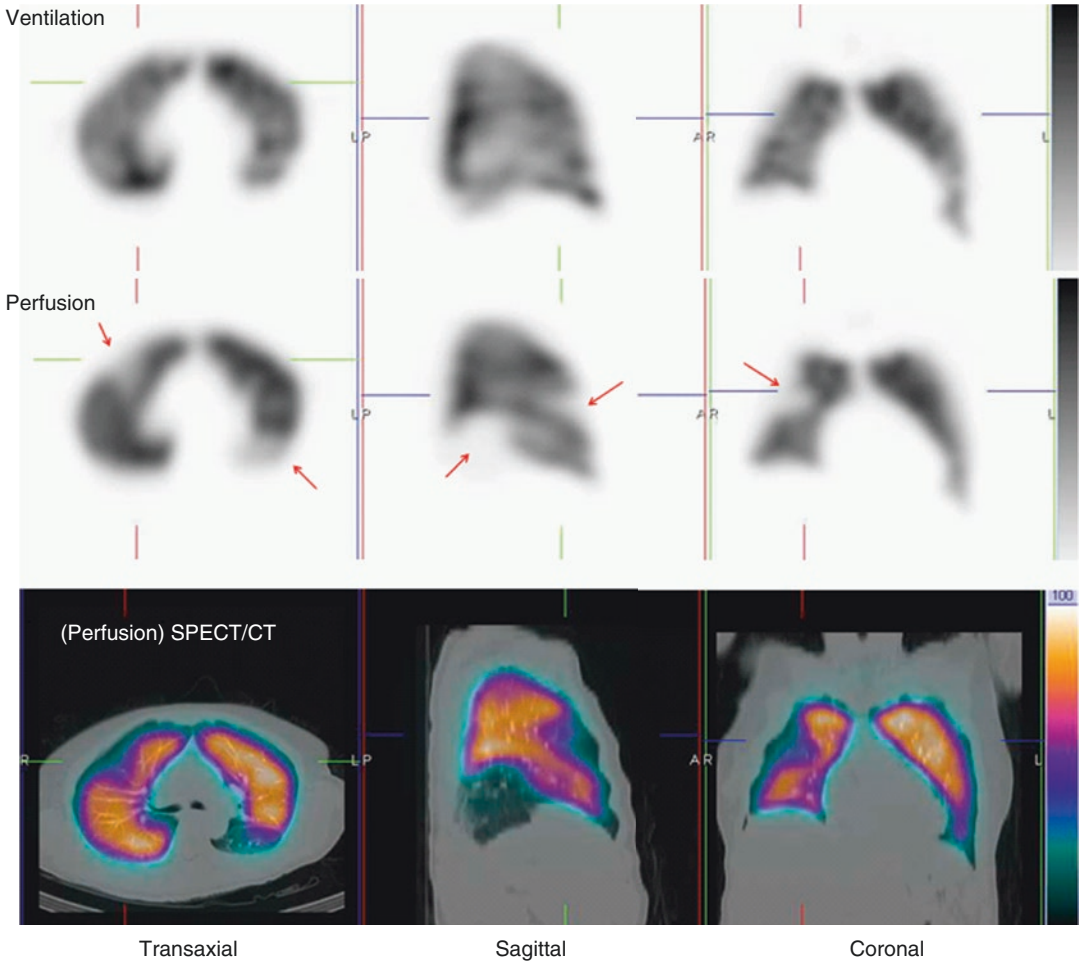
Representative ventilation, perfusion and fused SPECT/CT images in a patient with multiple PE. Several mismatched defects are evident (*arrowed*). There are no
